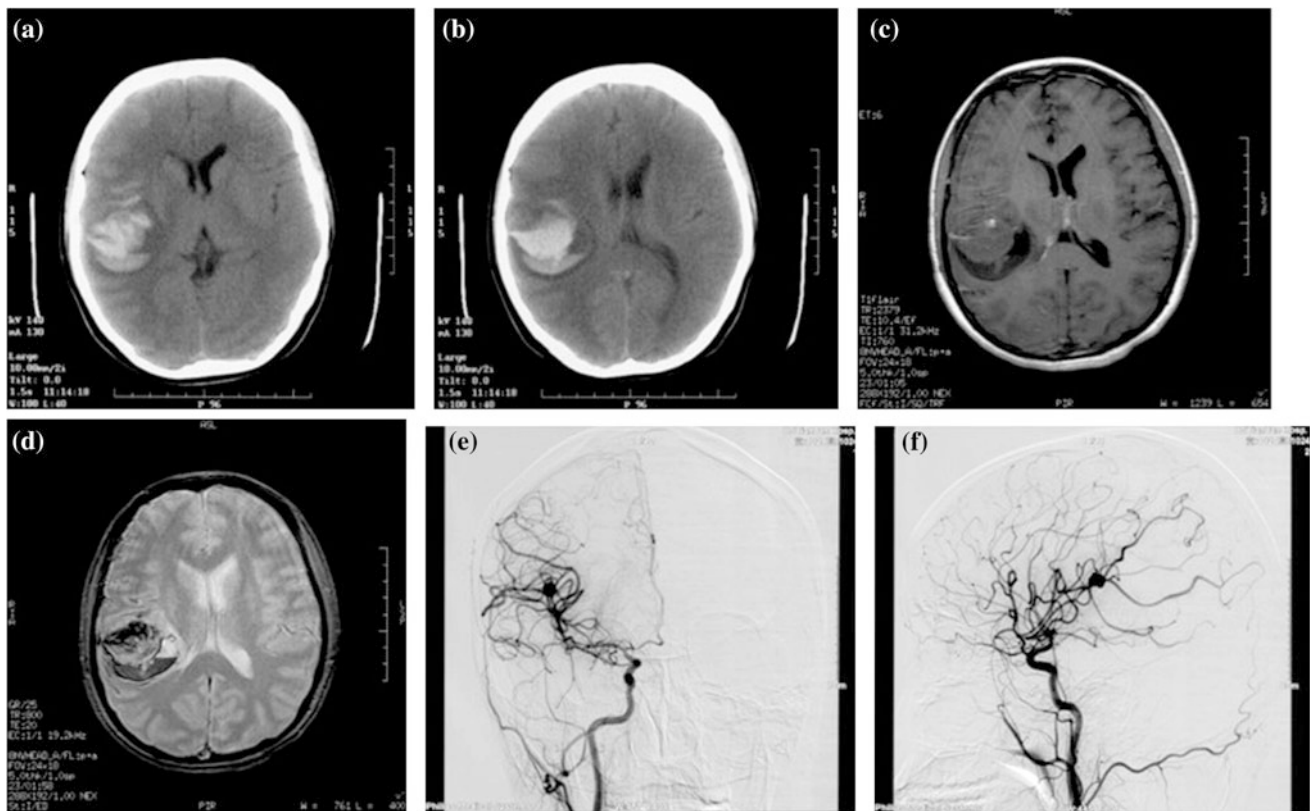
CNS complications of choriocarcinoma. Representative images of an aneurysmal hemorrhage from choriocarcinoma. a, b CT head shows an intraparenchymal hemorrhage in the right temporoparietal lobe with mass effect. Axial T1 MR imaging (c) and T2-weighted
